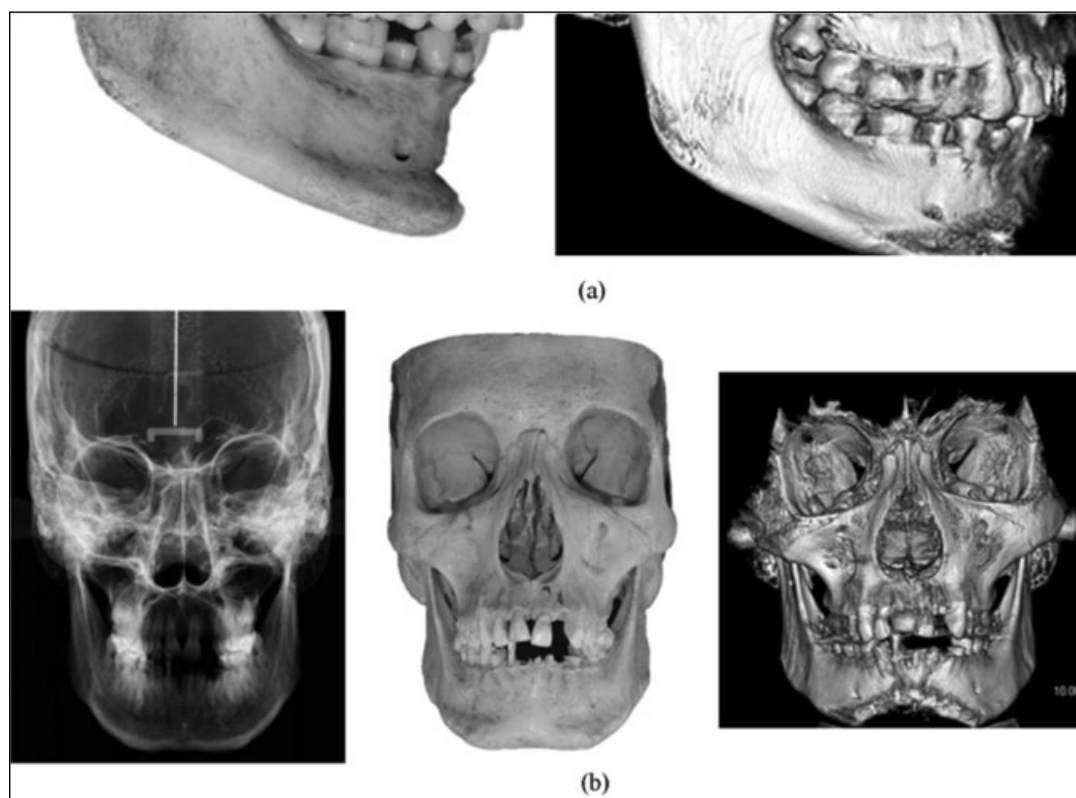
Comparative close-up of a skull for which no measurement was possible. (a) Lateral views in photograph (left) and surface rendering from CBCT (right); (b) Frontal views in PA cephalogram, photograph and surface rendering from CBCT (left to right).
